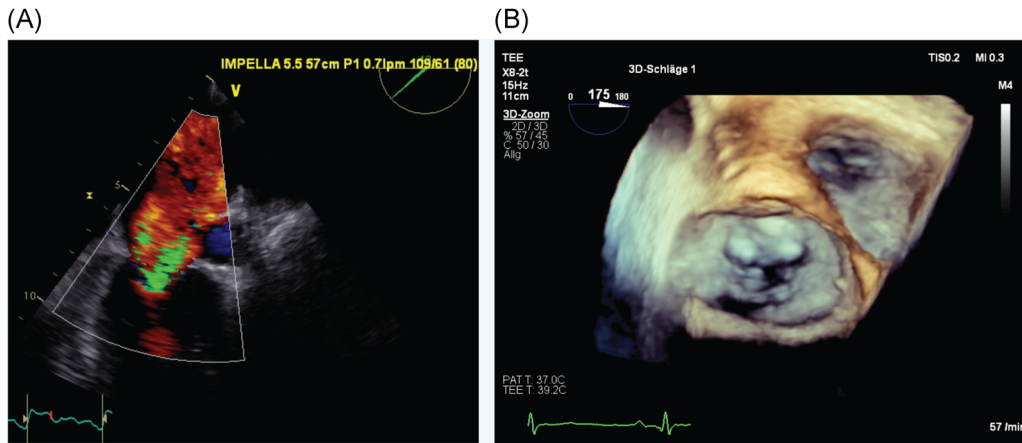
Preoperative echocardiography. Preoperative transesophageal echocardiography (TEE) showing severe mitral regurgitation due to leaflet tethering between A2-3 and P2-3 areas. Impella 5.5 flow was reduced to the P1 level (0.7 L/min) for the following diagnostics: (A) Intercommissural two-chamber view. (B) Three-dimensional reconstruction of the left atrium and mitral valve
